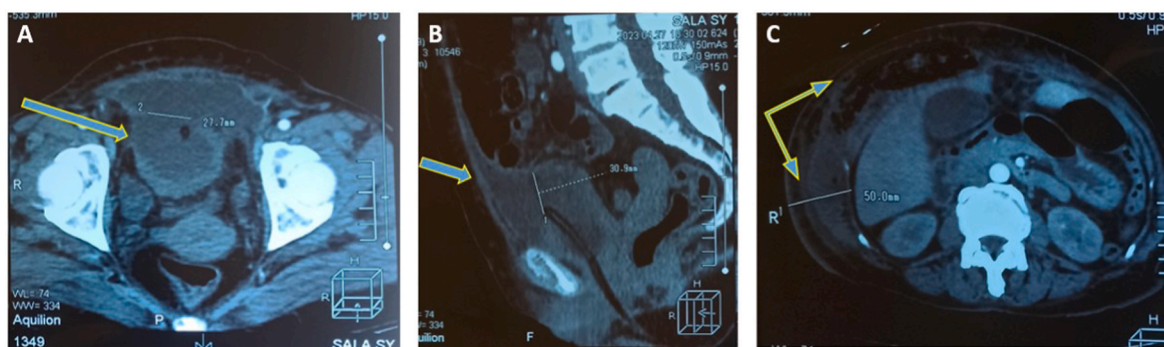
CT of the abdomen showing bladder rupture (A), extraperitoneal fluid collection (B), and a mixed fluid and gas collection in the abdominal wall (C).
